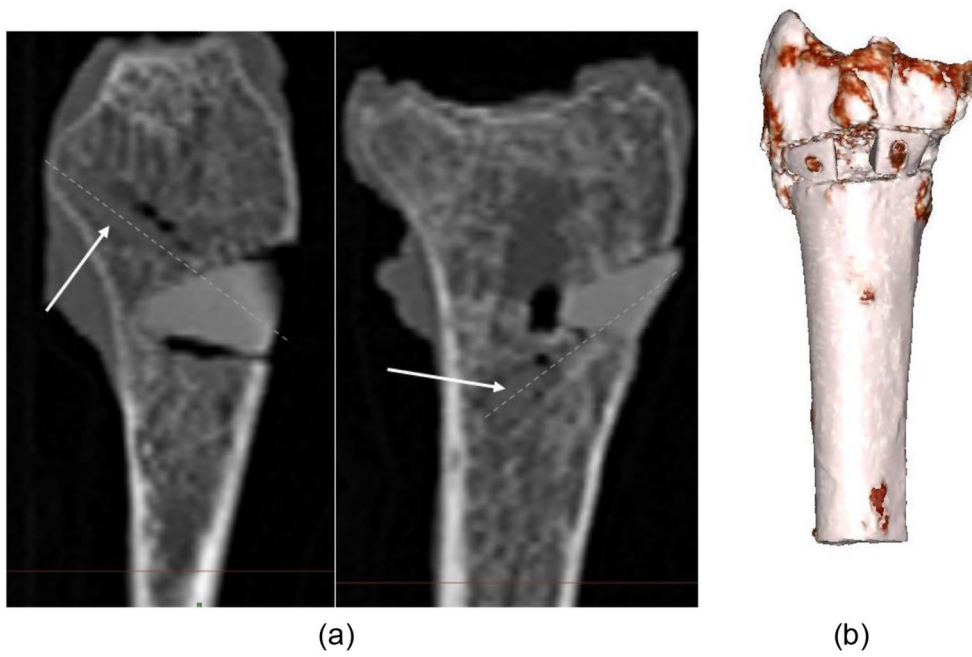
(a) Post-implantation CT scan of 1 L, screw anchoring. Dashed lines indicate the axis of the screw, (b) 3D reconstruction of post-implantation 1 L
